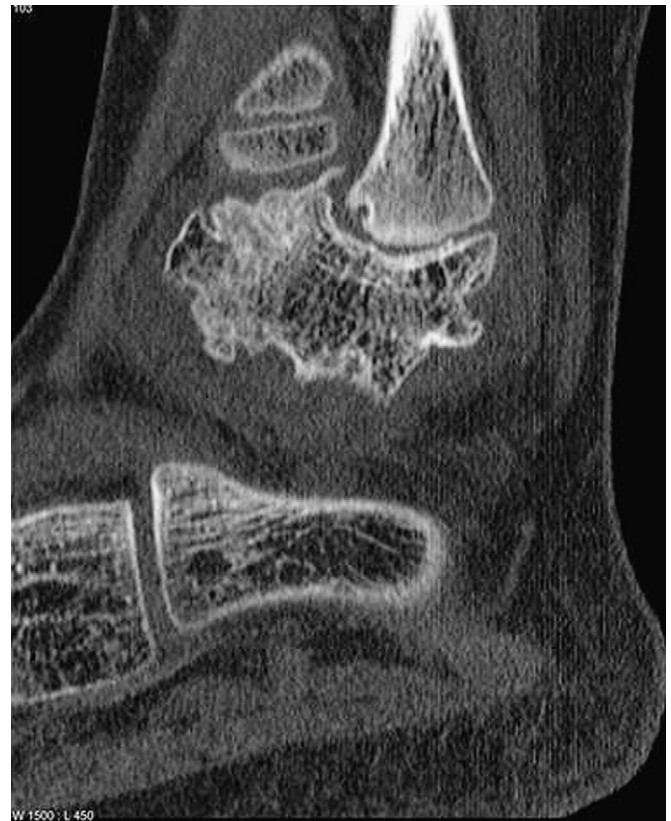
Sagittal reconstructed computed tomographic image of the right ankle.
